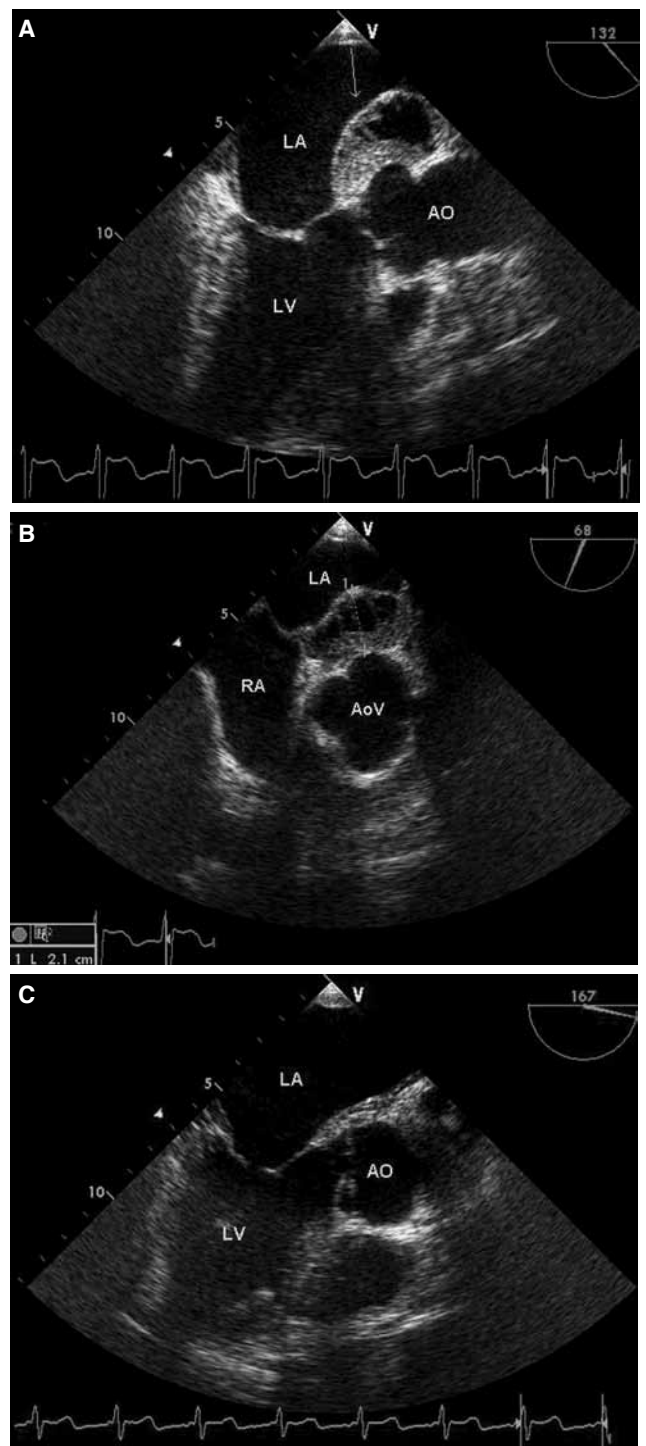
Transesophageal echocardiograms of the patient. Midesophageal aortic (A) long-axis and (B) short-axis views showing a septated mass (arrow) and mural thickening in the left atrial wall. (C) Midesophageal aortic long-axis view showing minimal residual thickening along the anterior left atrial wall. LA: Left atrium; LV: Left ventricle; AO: Aorta; AoV: Aortic valve.
